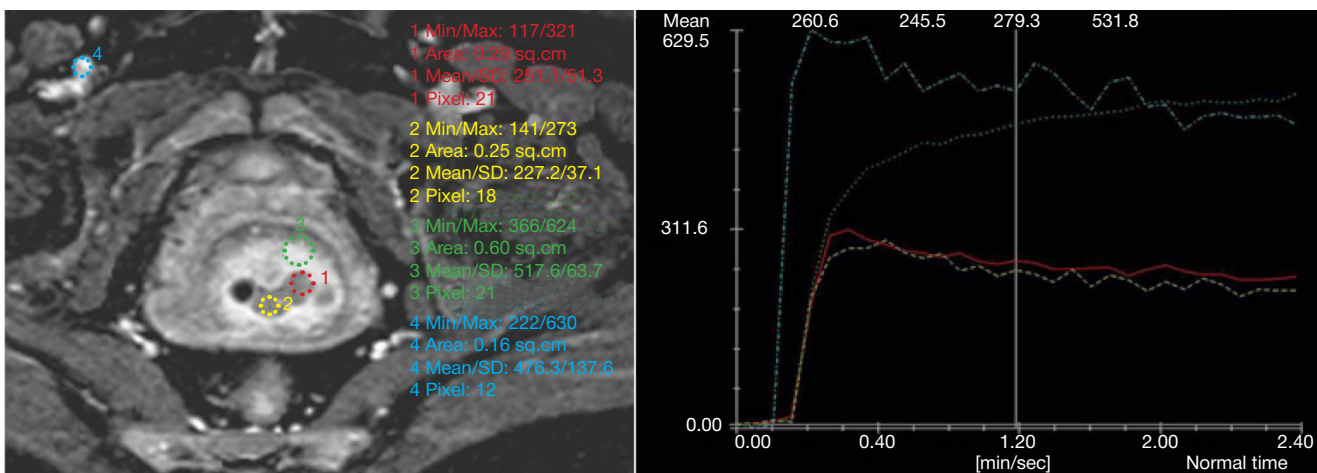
Magnetic resonance contrast agent accumulation curves obtained on the scanner workstation. An axial section is on the left, obtained from a dynamic contrast-enhanced MR image (80 s after scanning was launched) of a patient with squamous cell carcinoma. Regions of interest (ROIs) are shown in different colors. The yellow (1) and red (2) circles show cervical cancer, the green (3) circle shows intact myometrium, the blue circle (4) shows a blood vessel. Signal intensity-time curves based on the ROI data are shown on the right. The vertical line designates time elapsed after measurements were started (80 s). The horizontal axis shows time elapsed after contrast agent delivery to the tumor (seconds); the vertical axis shows relative signal intensity. A higher signal intensity is characteristic of intact myometrium and the vessel.
